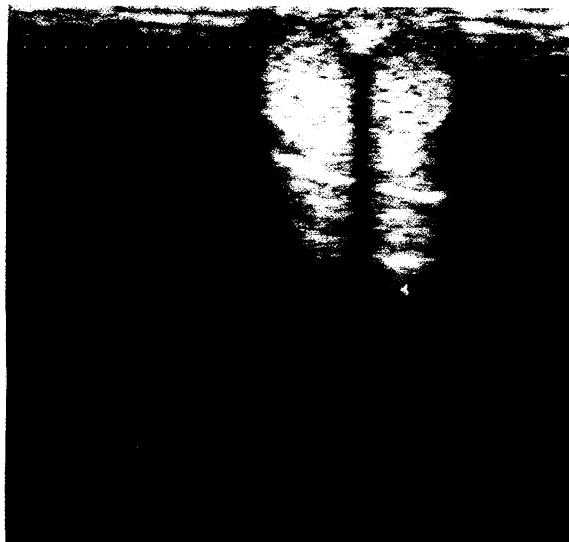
Ultrasonography of corpora cavernosa with thrombosis and beginning of fibrosis before therapy.
